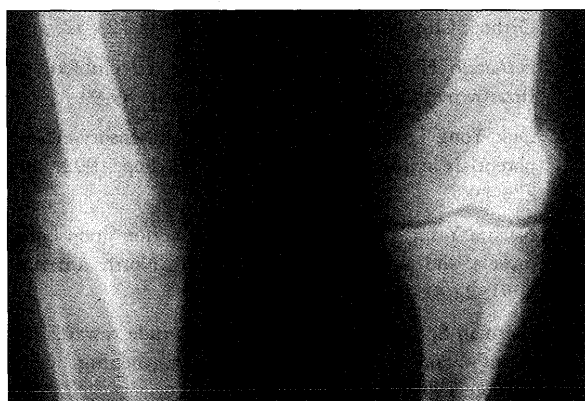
Standing radiograph of both knees after femoral bone transport with elective bone grafting upon docking.
